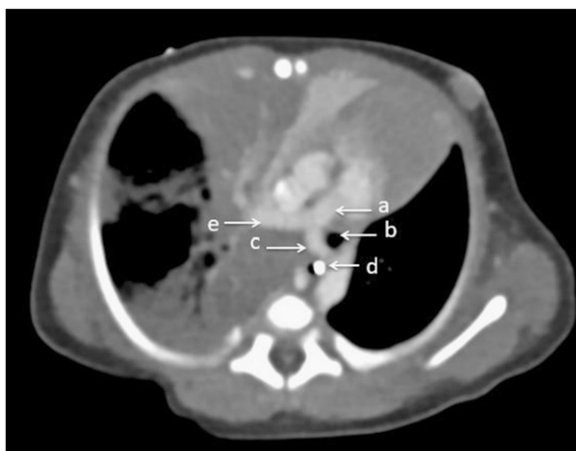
Axial view of chest computed tomography scan showing A) main pulmonary artery, B) trachea, C) left pulmonary artery with an abnormal origin from the right branch instead of the main pulmonary artery looping around the trachea forming a "sling," D) esophagus with enteric tube, and E) right pulmonary artery.
